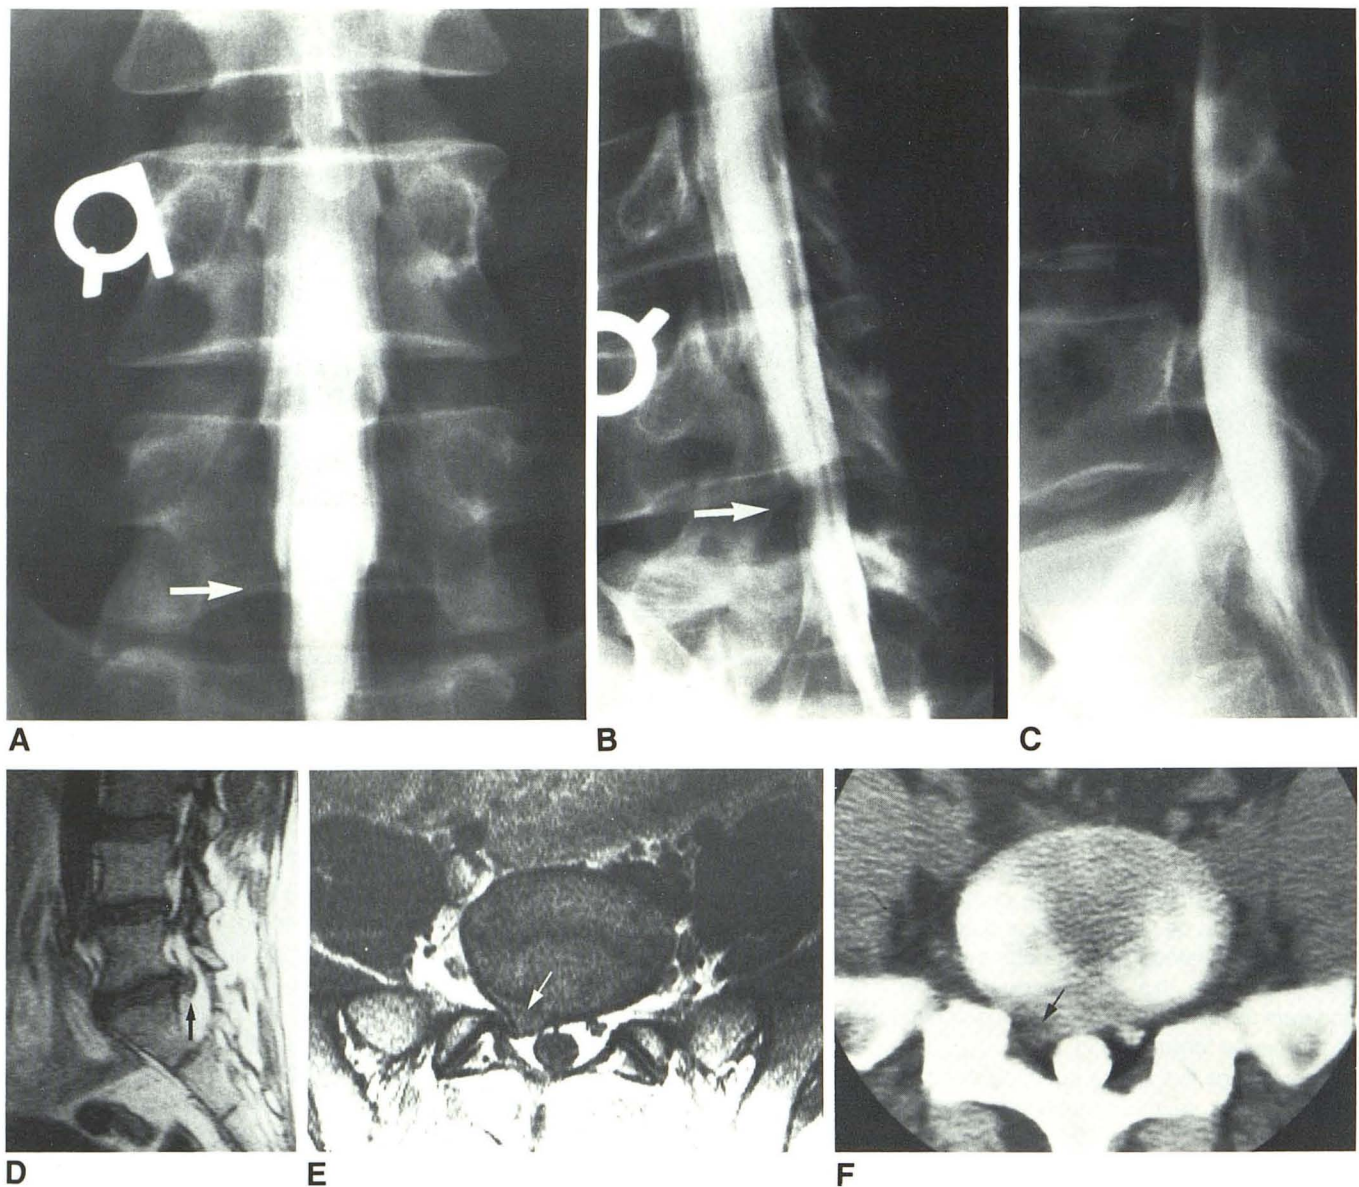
40-year-old woman with right S1 radiculopathy. A, B, and C, Anteroposterior lateral and oblique radiographs of lumbar spine from metrizamide myelogram. There is a subtle extradural defect involving right S1 nerve root on anteroposterior and oblique radiographs (*arrows*) and a mildly increased anterior extradural space at L5–S1 level on lateral radiograph. D, Parasagittal 4-mm MR section (TE = 30 msec, TR = 0.5 sec) 1 cm off midline. There is
